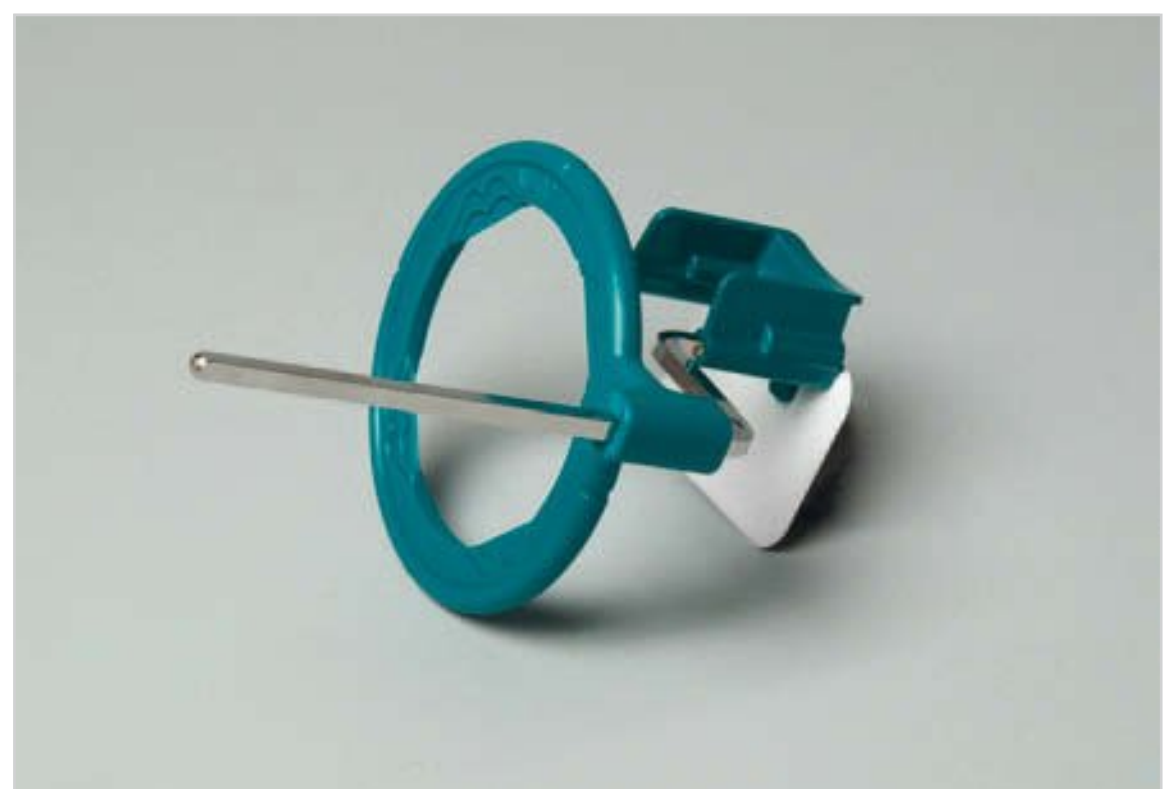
Dentsply Rinn Endo-Holder for radiographic measurement.
